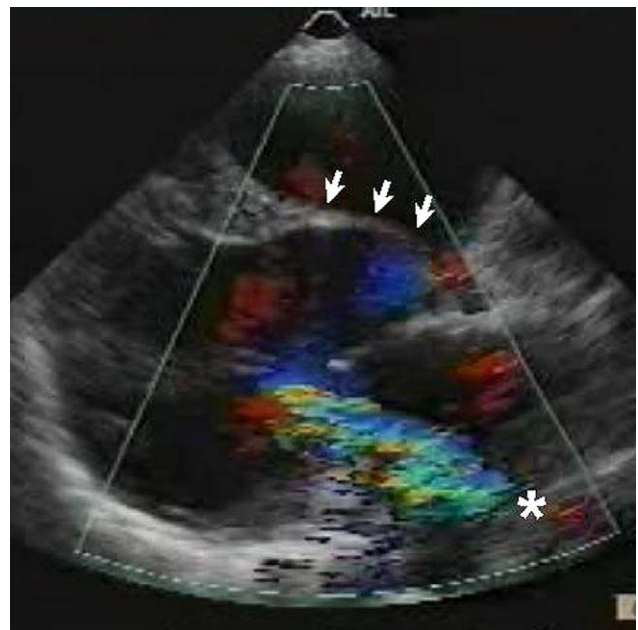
The long-axis view of the preoperative echocardiogram showing remarkable thinning of the basal septum (white arrows) and severe mitral regurgitation (asterisk).
